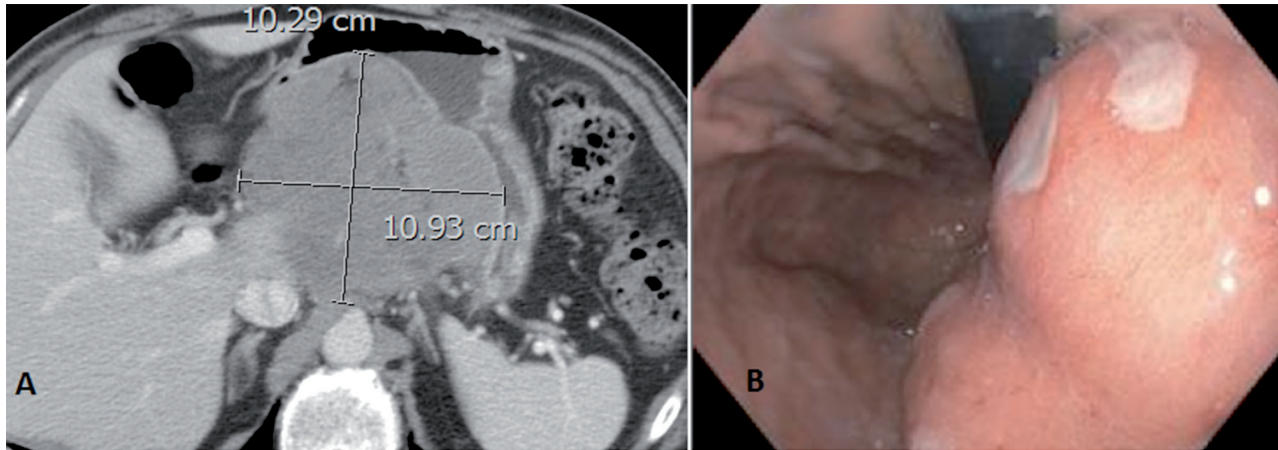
A: Abdomen CT showed an 11 cm mass along the lesser curvature of the stomach which encased the mesenteric vessels and appeared inseparable from the pancreatic body, gastric wall, and left hepatic lobe.
